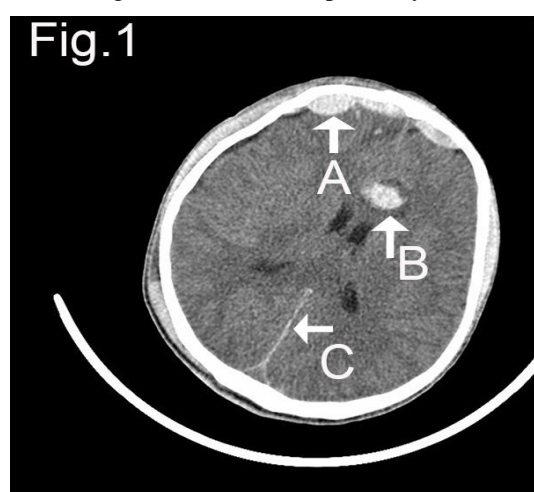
Computed tomography scan (CT) revealed a bilateral frontal hematoma (A), subdural hematoma (B), stem hematoma, subarachnoid hemorrhage (C) and diffuse parenchymal swelling.
